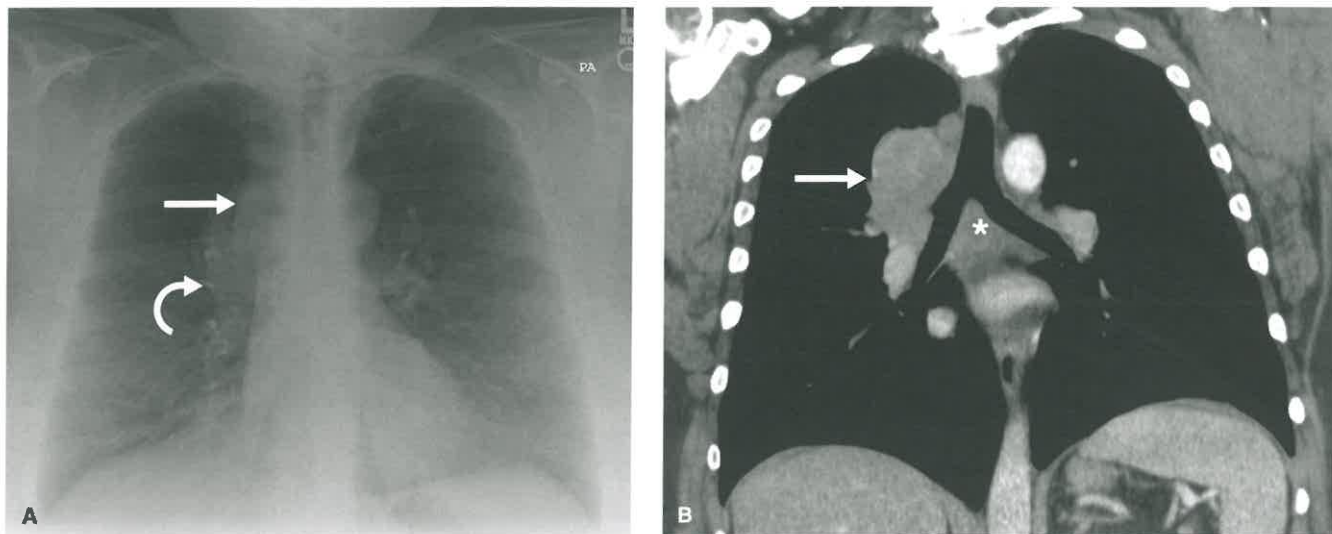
Middle Mediastinal/Hilar Lymph Node Enlargement From Small Cell Carcinoma of Lung. A: Frontal chest radiograph in a 46-year-old man with small cell carcinoma of lung shows right paratracheal (*straight arrow*) and right hilar (*curved arrow*) lymph node enlargement. B: Coronal contrast-enhanced CT scan at the level of the tracheal carina shows a lobulated right paratracheal and right hilar soft mass (*straight arrow*) with associated subcarinal lymph node enlargement (*asterisk*).
